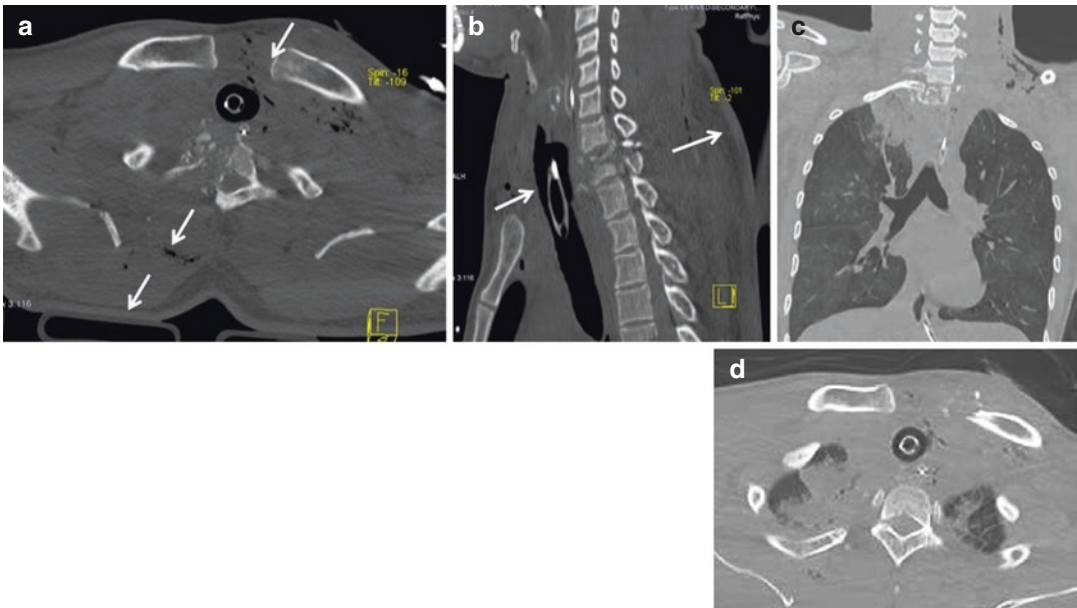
The wide disruption of soft tissues and of bones permits to depict quite exactly the projectile trajectory along the cervicothoracic outlet (*arrows*). In these axial (a–d), sagittal (b), and coronal (c), CT-scans we appreciate that the bullet entered from the anterior left
